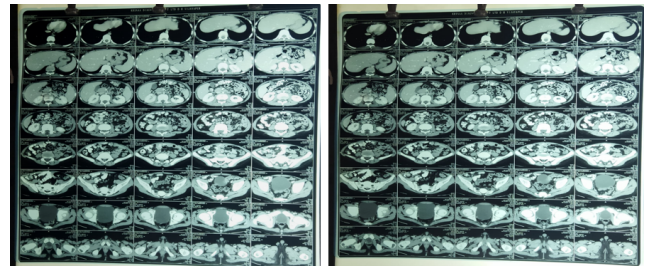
CT scan of abdomen showing diffuse wall thickening of right ileocolic junction and distal ileum
